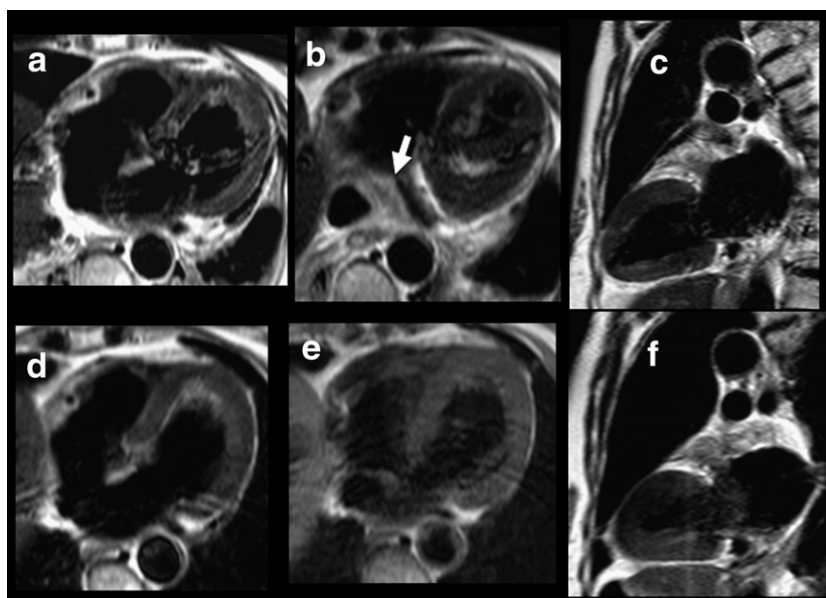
T2-weighted magnetic resonance images 4 days (a–c) and 8 days (d–f) after the initiation of R-CHOP therapy. Marked regression of the tumor was observed 4 days after the treatment (arrow) and complete disappearance of the tumor was observed 8 days after the treatment.
